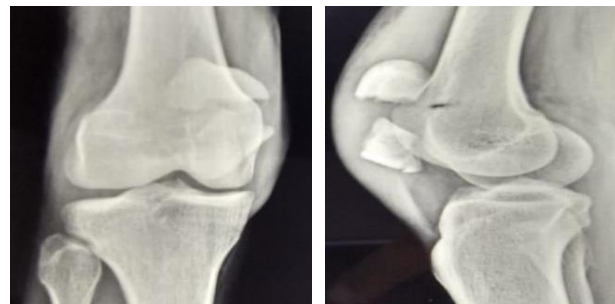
(A) Pre-operative radiograph (AP view). (B) Pre-operative radiograph (lateral view).
